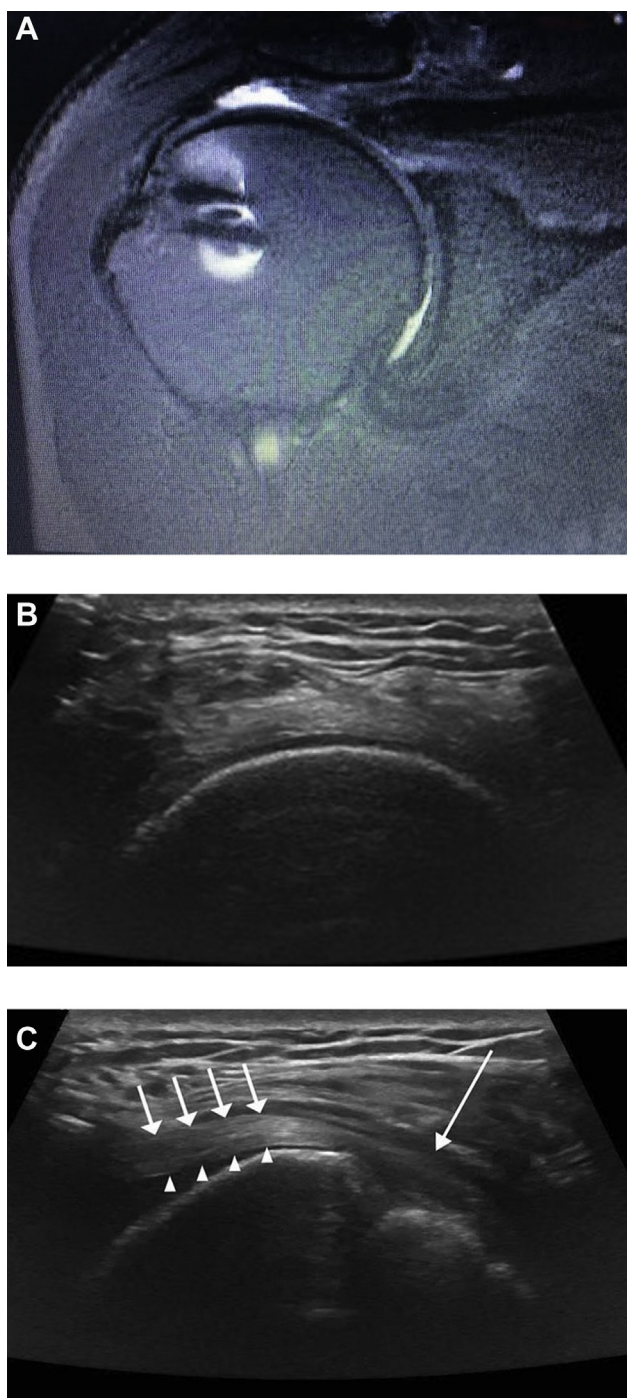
(A) A preoperative coronal T2 image showing hyperintense signal at the myotendinous junction of the supraspinatus muscle, indicative of a complete tear with the intact tendon remaining laterally attached to the tuberosity at the footprint. (B) Short-axis sonographic image of the supraspinatus tendon that demonstrates the supraspinatus tendon intact inferiorly and the respectively superficial dermal allograft is also intact. (C) Long-axis sonographic image of the supraspinatus tendon of the same patient postoperatively after dermal allograft augmentation. —: rotator cuff footprint with the intact tendon attached to the footprint. →: supraspinatus tendon allograft. ▲ native supraspinatus tendon fibers inferior to the graft.
